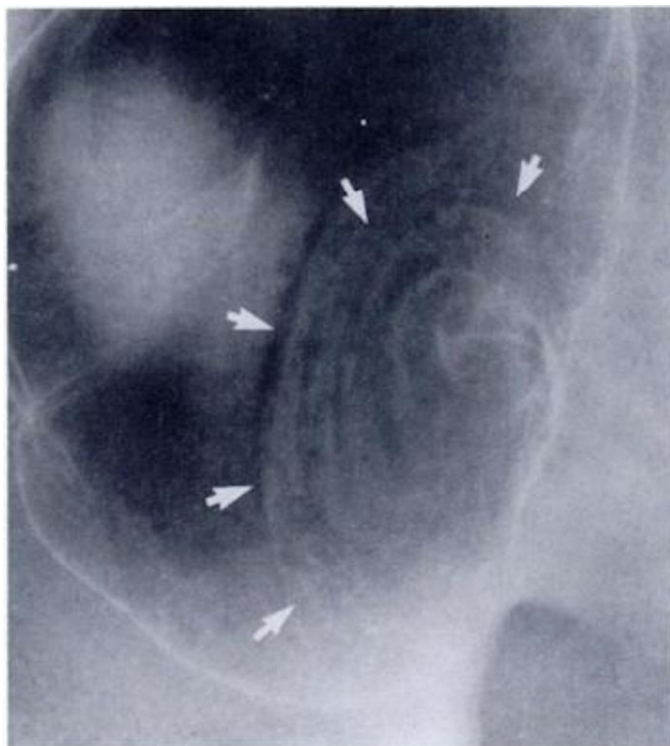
(left): Transient appendiceal intussusception in an asymptomatic patient. Findings: Spot radiograph from double contrast barium enema reveals a coiled-spring defect in cecum (arrows) with nonfilling of the appendix. Technique: Frontal, magnified radiograph of the right lower abdominal quadrant using intraluminal barium contrast and air. kVp 90; mAs 40. (Reprinted by permission: Levine MS, Trenkner SW, Herlinger H, et al. Coiled-spring sign of appendiceal intussusception. *Radiology.* 1985; 155:41-44.)
